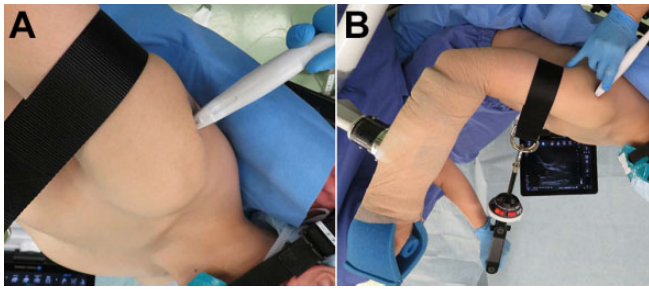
Positions of the arm and ultrasound probe during ultrasound measurements. (A) Anterior shoulder translation was measured with the forearm fixed and elbow positioned at 90° of flexion in the beach-chair position with the back of the bed flexed at 45° under general anesthesia. Another third proximal humeral line was drawn anteriorly with 40-N forces using a dynamometer at 0°, 45°, and 90° of shoulder abduction. (B) An ultrasound probe was set parallel to the scapular spine from the posterior part of the shoulder.
